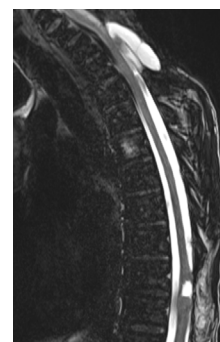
Sagittal T2W MRI shows an intradural extramedullary lesion at T2 and T9-T10 levels.
